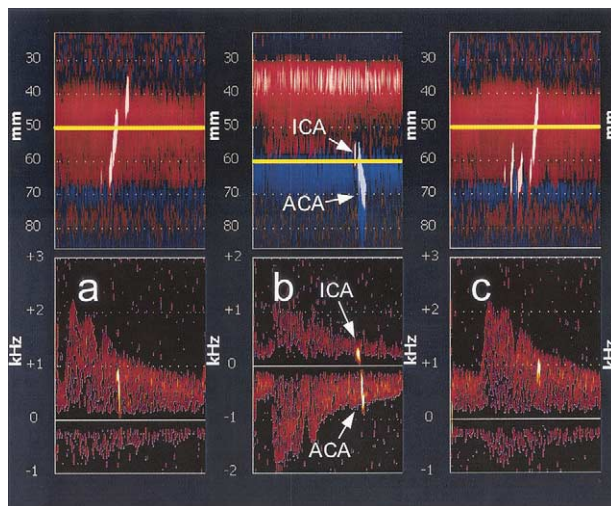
Complex embolus behavior demonstrated by PMD display: (a) Embolus coming to ~50 ms rest in MCA and then continuing into distal MCA segment. (b) Embolus movement from ICA to ACA. (c) Multiple emboli, one of which traverses the MCA and the Doppler sample volume associated with the spectrogram.
